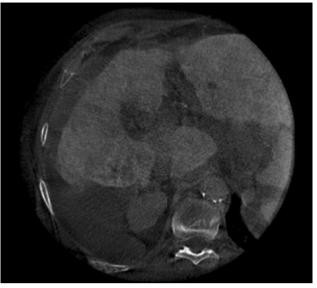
Dual-phase cone beam CT confirmed the lesion – Delayed phase 3 mm MPR
